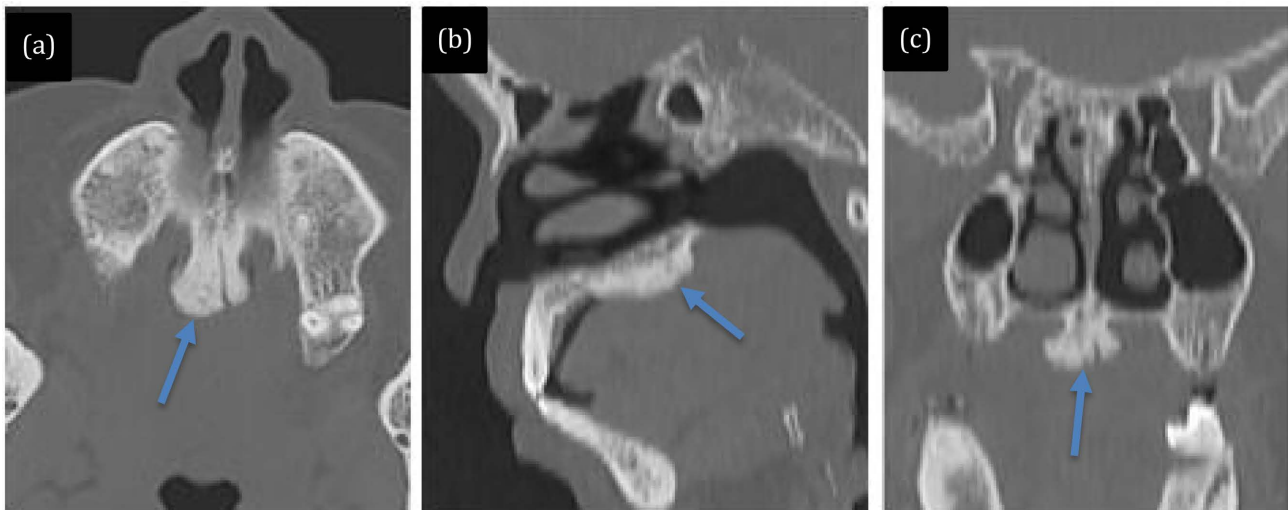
Computed tomography scan of an isolated palatal torus. (a) axial section, (b) sagittal reconstruction, (c) coronal reconstruction. Palatal torus (blue arrow).
